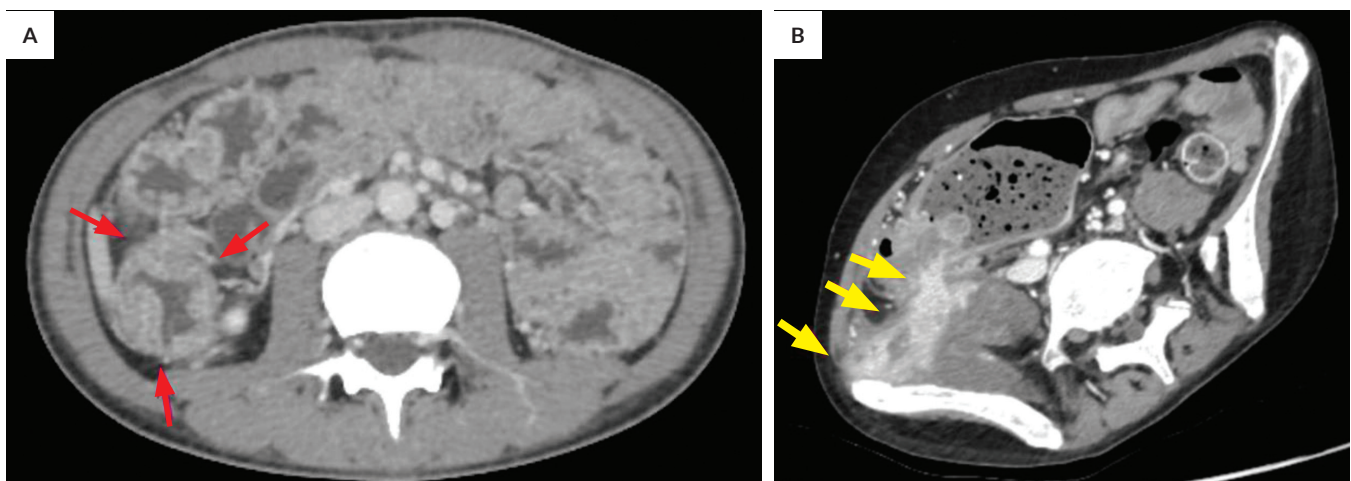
Abdominal CT scan findings of pediatric patients with inflammatory bowel disease. (A) Irregular thickening and hyper-enhancement of the mucosa of the sigmoid colon (red arrows) in a 15-year-old male patient with ulcerative colitis presenting with 1-year history of bloody diarrhea, abdominal pain and weight loss. (B) Irregular enhancing tracts from the ileo-cecal wall thickening with communications through the right iliopsoas and through the cutaneous layer (yellow arrows) at the right lower quadrant in the 18-year-old male patient described in Figures 3A and 4B.
